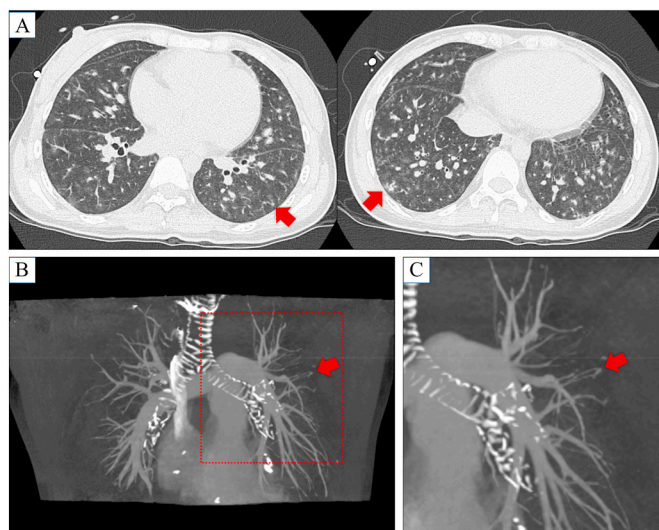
Enhanced chest computed tomography (CT) shows diffuse anastomoses of peripheral pulmonary arteries and veins. Small pulmonary arteriovenous malformations are found in both lungs (arrow) (A). Four-dimensional reconstructed enhanced chest CT scans reveal multiple abnormal communications between the peripheral pulmonary arteries and veins (arrow) (B, C).
